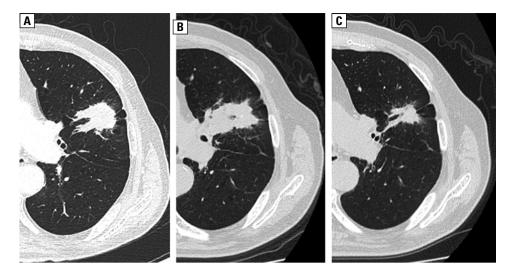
Chest CT scan at the time of the diagnosis of lung adenocarcinoma (A), chest CT scan taken 19 months after the diagnosis of lung adenocarcinoma (B), and spontaneous regression of the mass was identified on a chest CT scan 27 months after the diagnosis of lung adenocarcinoma (C)
